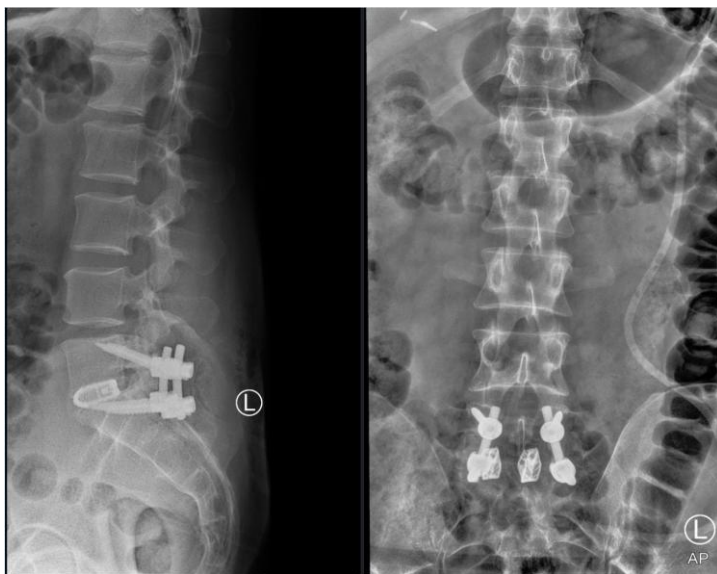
MIDLIF postoperative anteroposterior and lateral radiographs
